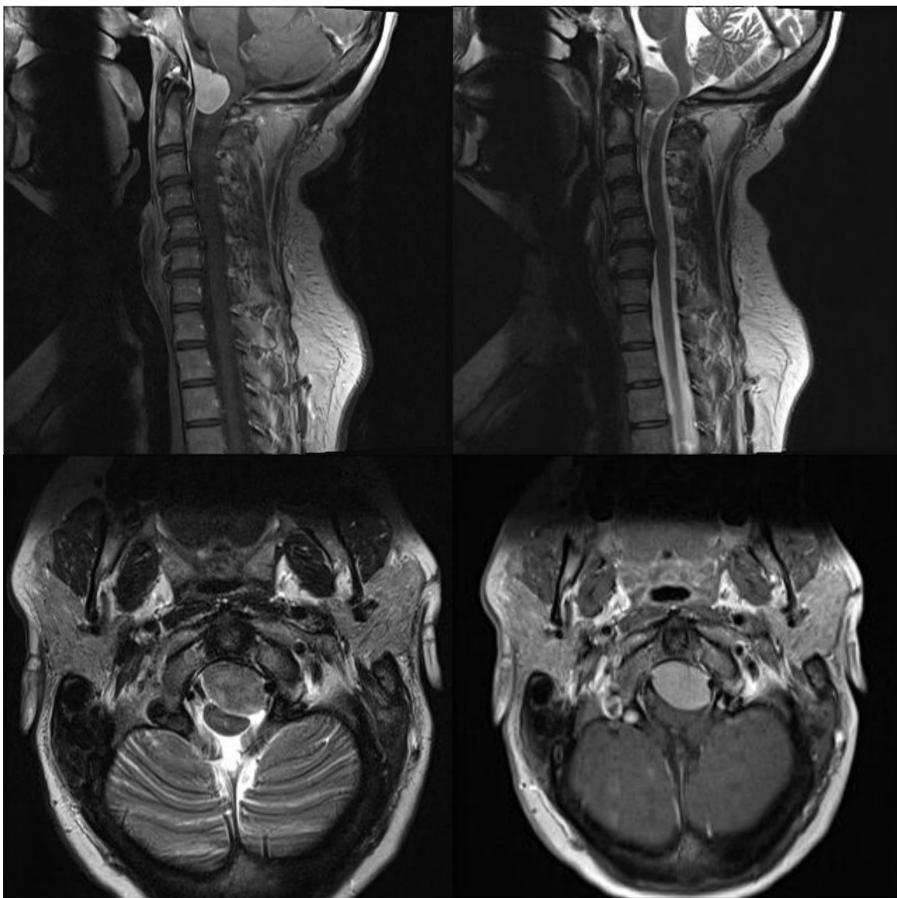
Preoperative MRI. Sagittal contrast-enhanced T1-weighted sequence (upper left) and T2-weighted sequence demonstrate a ventral foramen magnum meningioma with significant spinal cord compression. Axial T2 (lower left) and contrast-enhanced images (lower right) again demonstrate the tumor, predominantly left-sided.
